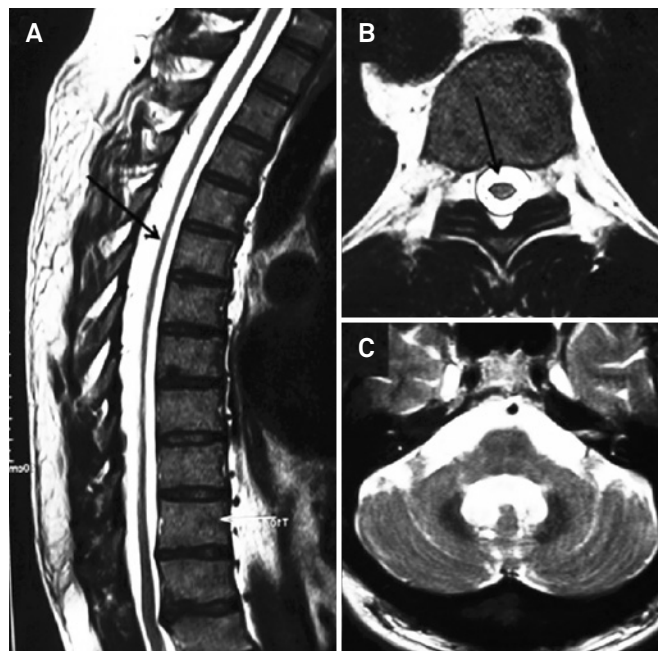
Sagittal T2-weighted spine MRI demonstrates global spinal cord atrophy; B. Axial T2-weighted spine MRI shows a marked reduced transverse diameter of the thoracic spinal cord; C. Axial T2-weighted brain MRI discloses moderate olivopontocerebellar atrophy.
